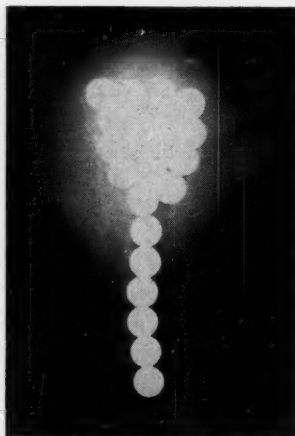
Radiographic study of beads in situ. Lateral view.
